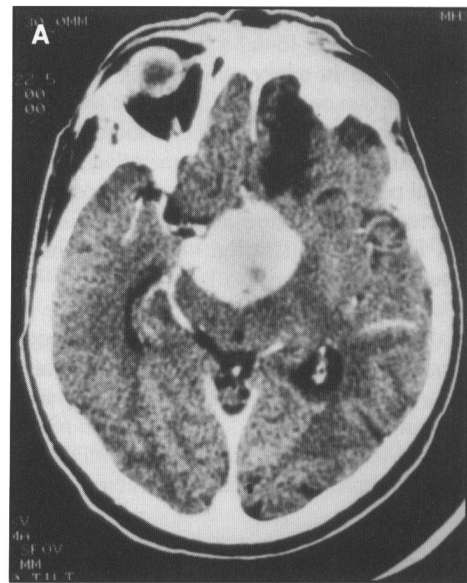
The preoperative CT scan of a male with a non-secretory pituitary tumor (please note the left frontal hypodensity related to the previous subfrontal resection).
